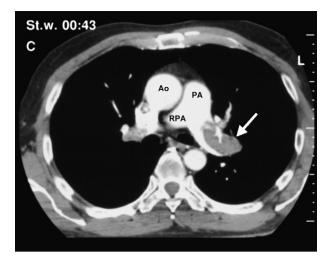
Computed tomography demonstrating thrombotic material in both pulmonic arteries; occlusion in of the left pulmonary artery is demonstrated (arrow). RPA = right pulmonary artery, Ao = ascending aorta.
